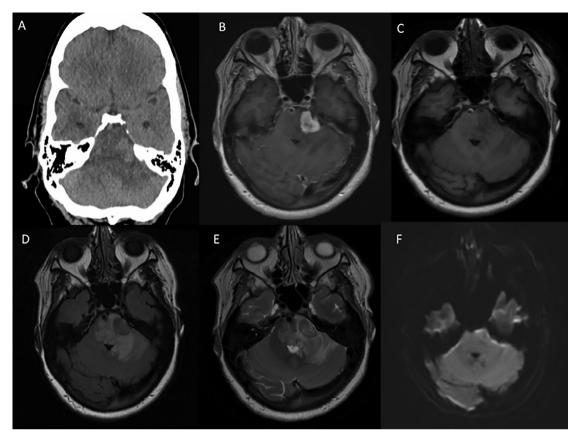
A. Axial CT with hyperdense lesion at the left CPA, B. Axial T1 weighted magnetic resonance imaging with gadolinium contrast, showing involvement of the left trigeminal nerve C. Axial T1 weighted magnetic resonance imaging post contrast, D. Axial T2 weighted magnetic resonance imaging FLAIR showing extensive vasogenic oedema, E. Axial T2 magnetic resonance imaging seemingly showing a cleft of CSF around the lesion, F. Diffusion weighted imaging showing mild restriction.
